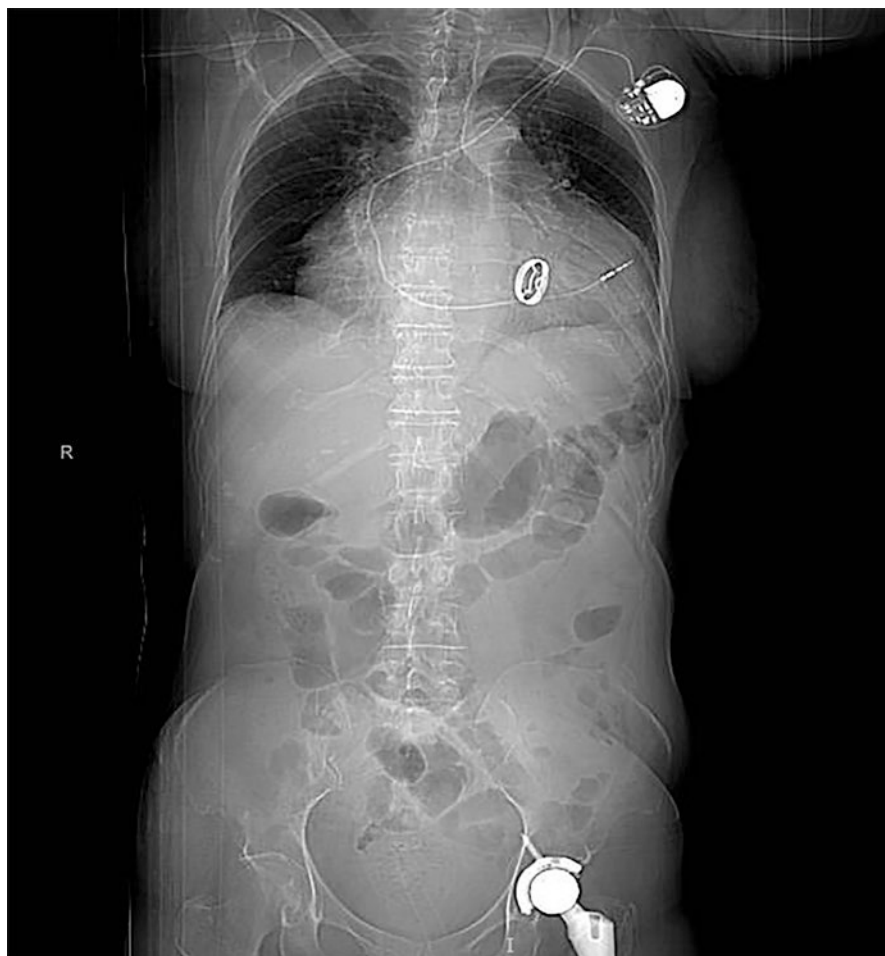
CT scan of the patient described in Fig. 16.8 mitral prosthetic mechanical valve, total hip replacement, and a VVI pacemaker can be appreciated
